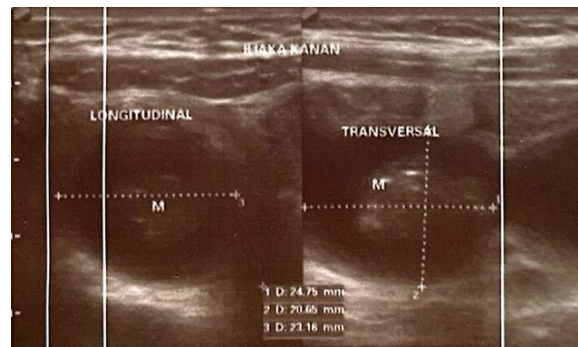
Ultrasonografi showed a mass in the right iliac region.
